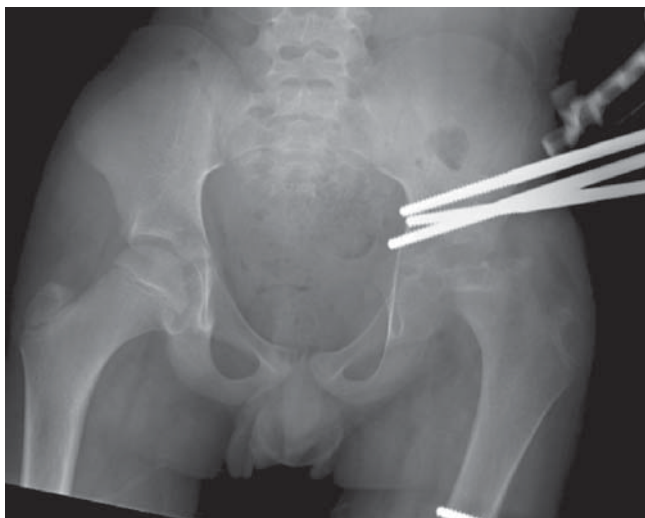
Follow-up radiograph 6 weeks postoperatively demonstrating an adduction deformity of the left lower extremity with no significant distraction at the hip joint
